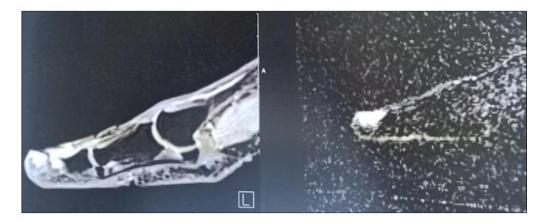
MRI (T2) shows subungual tumor of the great toe measuring 12 mm long axis
